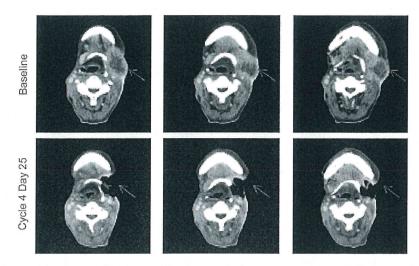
Antitumor activity with buparlisib (100 mg /day) in a patient with head and neck squamous cell carcinoma and metastasis to the neck lymph node. A 58-year-old male patient experienced a 76% reduction in neck lesion size (from 59 mm at baseline to 14 mm in Cycle 4). As the second confirmation according to Response Evaluation Criteria In Solid Tumors was not obtained, this unconfirmed partial response was recorded as stable disease. The left internal carotid artery was compressed and narrowed by the tumor. During study treatment, fistulae developed in the skin of the neck region followed by arterial hemorrhage from the rapidly degraded tumor lesion. Although the patient recovered and restarted buparlisib at 50 mg/day in Cycle 5, they eventually died from hemorrhage 5 days after buparlisib discontinuation, which was considered unrelated to the study drug. Sequential images of computed tomography scans taken at baseline and on Cycle 4 Day 25 are shown. The arrow marks the region of interest.
